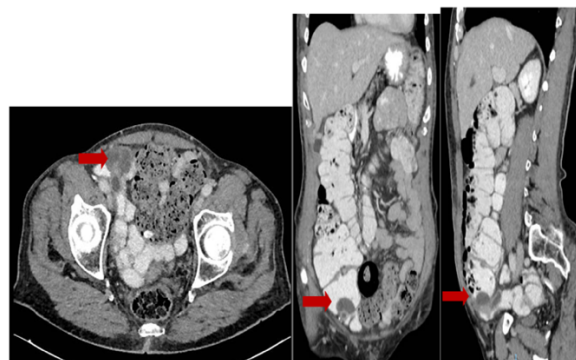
CT Abdomen and Pelvis with IV and oral contrast.
